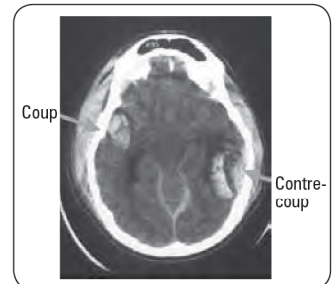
CT showing coup-contrecoup injury
